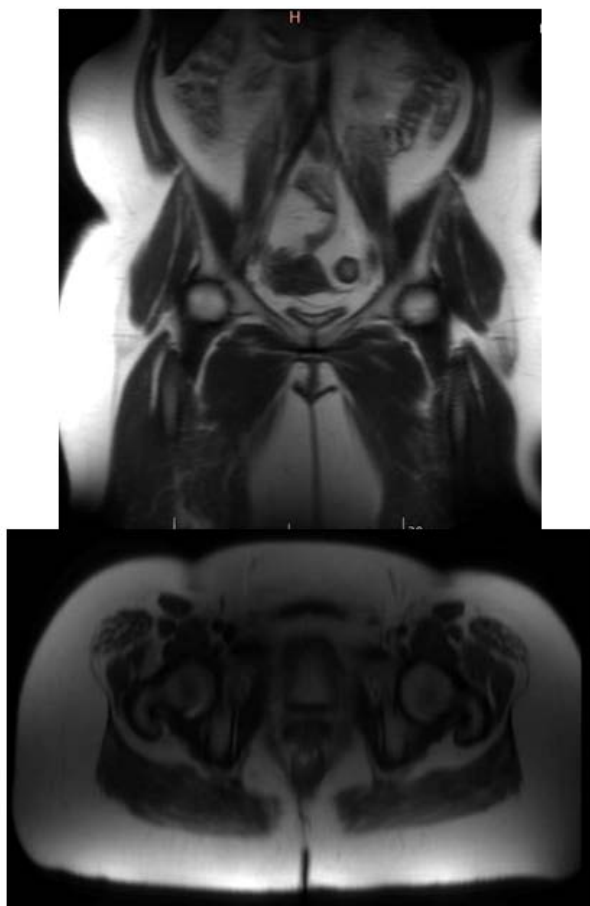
(A) 3/6/2023 MRI of pelvis- no mass in cervix or vagina. (B) Decreased and resolved pelvic nodes
